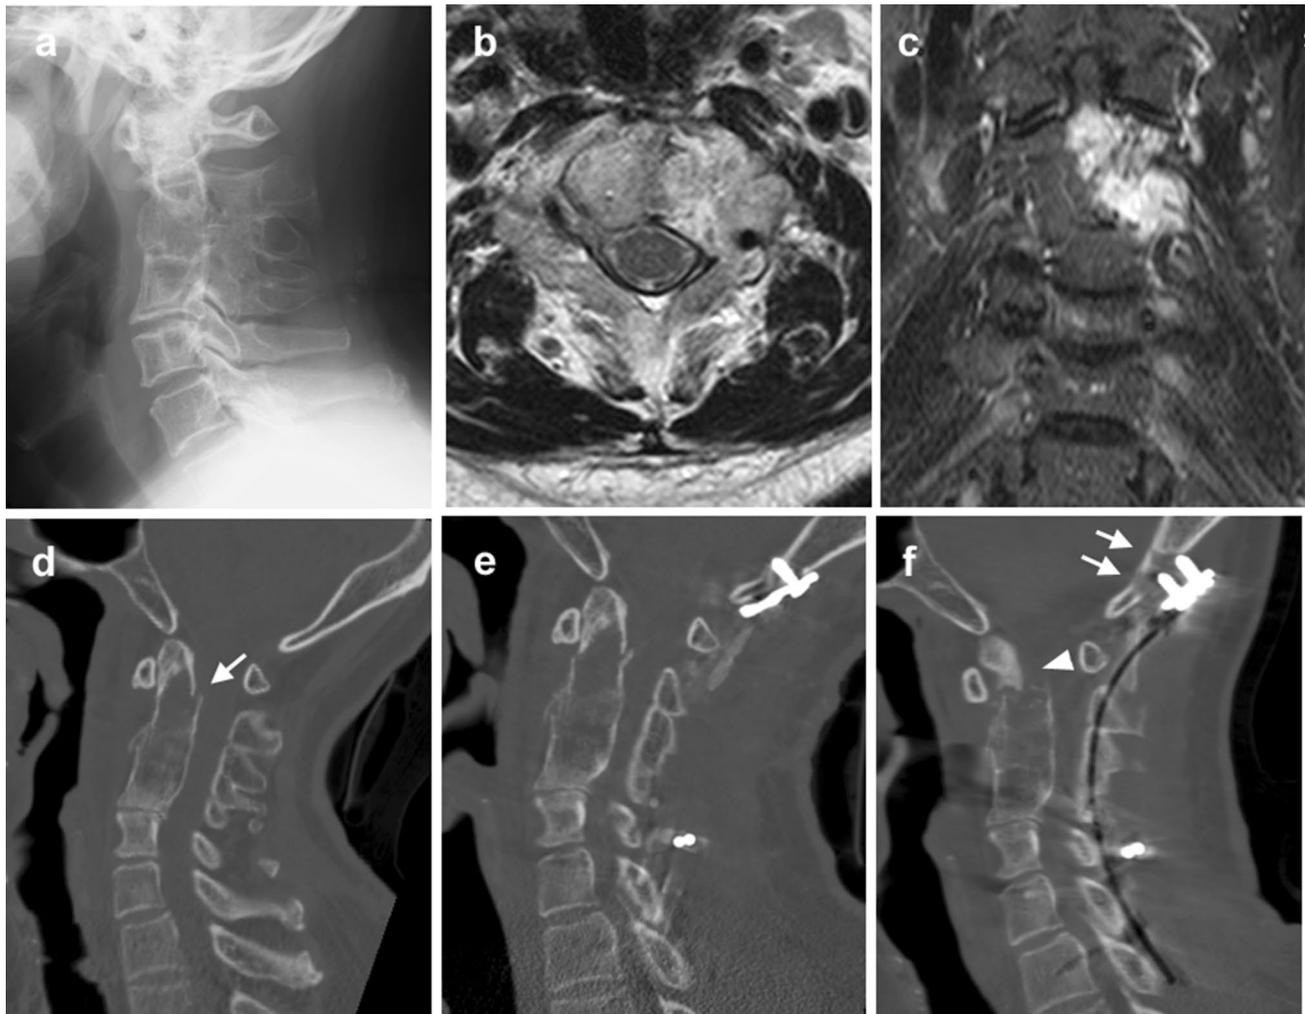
A 61-year-old man with chordoma. a Plain radiographs showing spontaneous spinal fusion at C2–C5 with kyphotic deformity along the osteolytic destruction of the C2 and C3; on axial (b) and coronal (c) T2-weighted MRI, the tumor extension from C2 to C4
